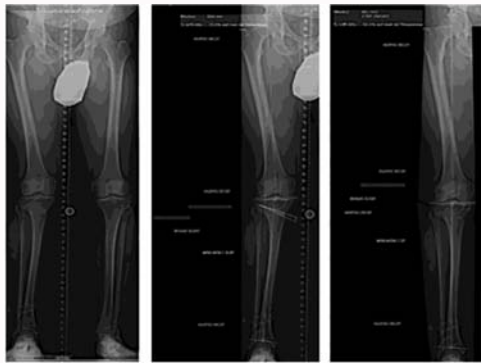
A preoperative full-length weight-bearing radiograph. Analysis showing the valgus alignment due to an overcorrection during the HTO. The planning of the anteromedial closed wedge HTO to restore a normal alignment and mMPTA.
